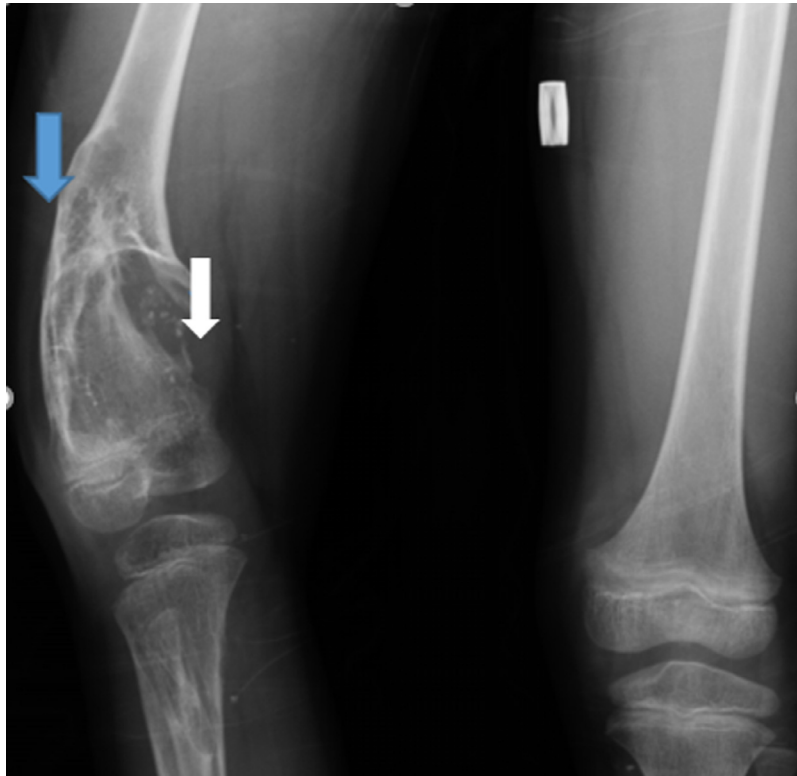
Plain radiograph of the right thigh showing a heterogeneous osteolytic lesion surrounded by a sclerotic rim (blue arrow) this expansile lesion is responsible for cortical rupture on the medial aspect of the bone (white arrow).
